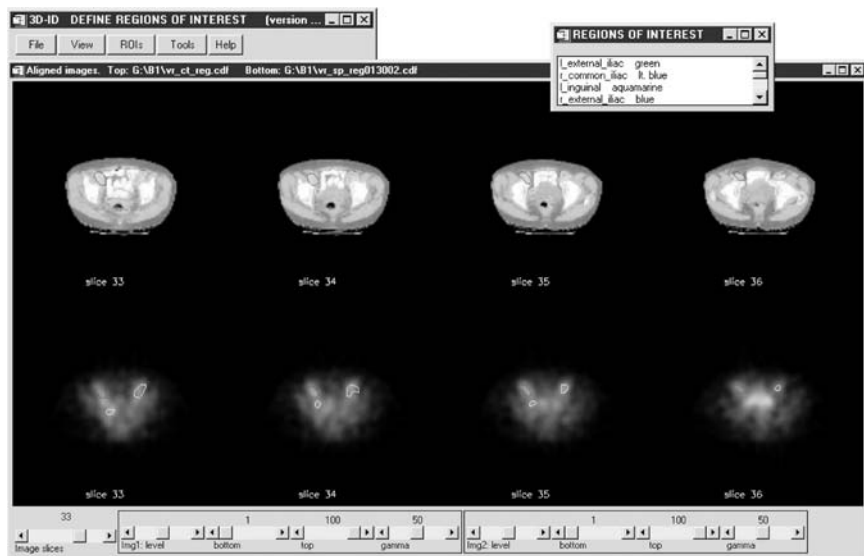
Multi-image display from 3D-ID showing four transverse slices from a set of CT-SPECT aligned images. The top row shows the CT with ROIs drawn over three lesions identified as: right external iliac in blue, left external iliac in green, and right common iliac in light blue. The bottom row shows the corresponding ^{131}I SPECT slices with the lesions indicated. (See plate 3 for colour version.)
